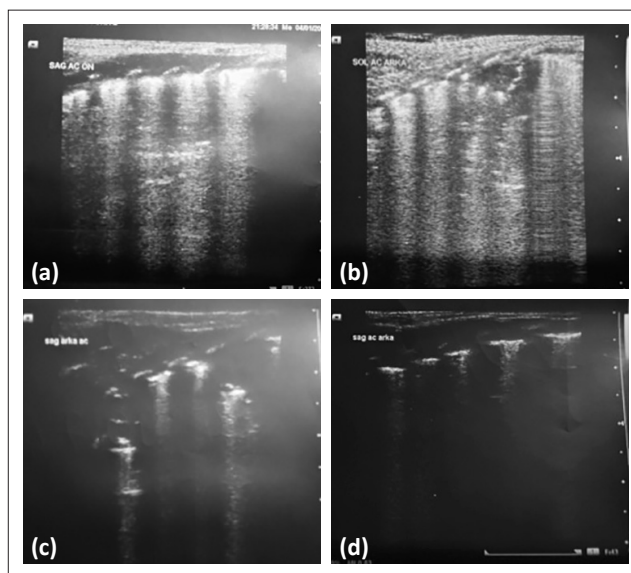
(a) Lung USG of the male patient before stem cell treatment (lung ultrasonography reveals prominent B lines, pleural line is not regular, there are consolidation areas involving air bronchogram, A lines, which are observed in normal lung tissue, are absent). (b) Lung USG of the female patient before stem cell treatment (lung ultrasonography shows irregularities in lung parenchyma and pleural line. Widespread B lines and consolidation areas involving air bronchogram are present. A lines, which are observed in normal lung tissue, are absent). (c) Lung USG of the female patient 15 days after stem cell treatment (irregularities in lung parenchyma and pleural line persist on lung ultrasonography. There is a reduction in the number of B lines and the appearance of A lines is increased. However, the clinical findings of this patient had a more severe course in accordance with the ultrasonographic imaging compared with her brother). (d) Lung USG of the male patient 15 days after MSCs treatment (lung ultrasonography revealed that the number of B lines was reduced, the ‘lung sliding’ sign developed, A lines appeared, comet tail was observed in the area of imaging, and consolidation areas were deleted)
